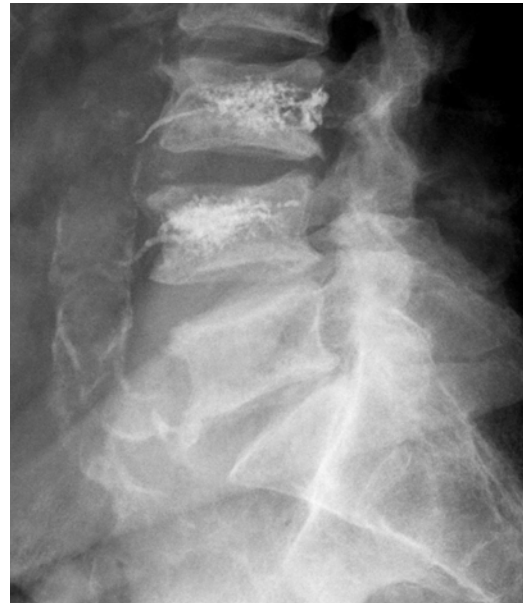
X-ray film of the lumbar spine showing cement leakage after vertebroplasty.
